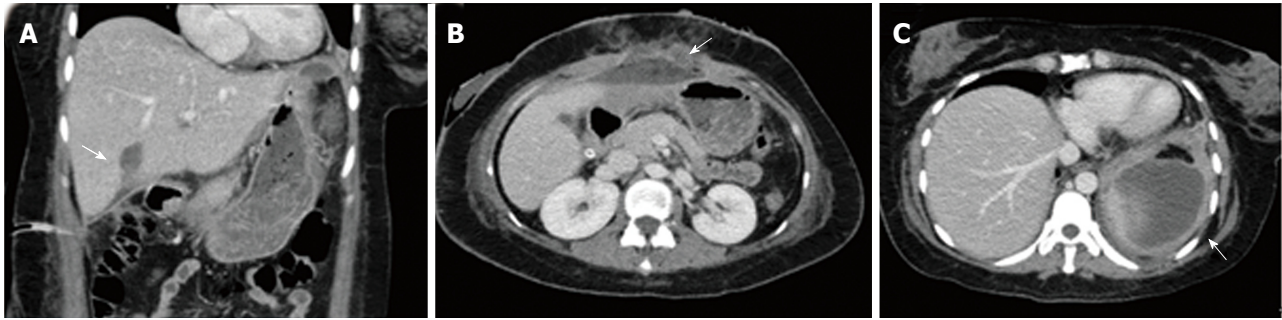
Computed tomography scan. A: Initial computed tomography scan of the abdomen revealing a 3 cm biloma at the gallbladder fossa with bile tracking into the sub-hepatic recess; B: Multiple rim-enhancing smaller intra-abdominal collections were also present in the upper abdomen; C: The largest intra-abdominal collection was a 9.3 cm × 8.5 cm perisplenic collection.
